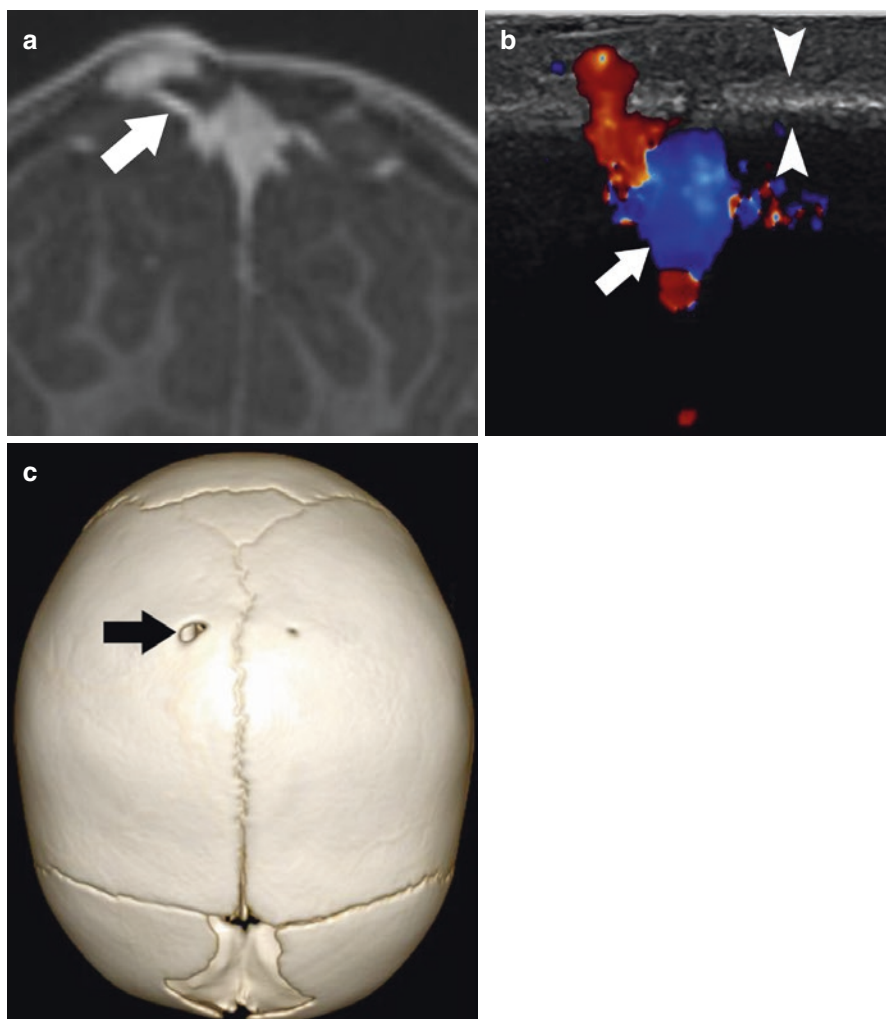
Sinus pericranii in a 13-month old. (a) Coronal thin post contrast T1 weighted image shows a right parietal epicranial venous pouch communicating with the superior sagittal sinus through a small intra-osseous vein (*arrow*). (b) Coronal color Doppler ultrasound shows the intraosseous course of the vein and the superior sagittal sinus (*arrow*). Note the hyperreflective calvarium (*arrowheads*). (c) Volume-rendered 3DCT shows an enlarged osseous channel (*arrow*) associated with the sinus pericranii (compare with the normal parietal foramen on the left)
